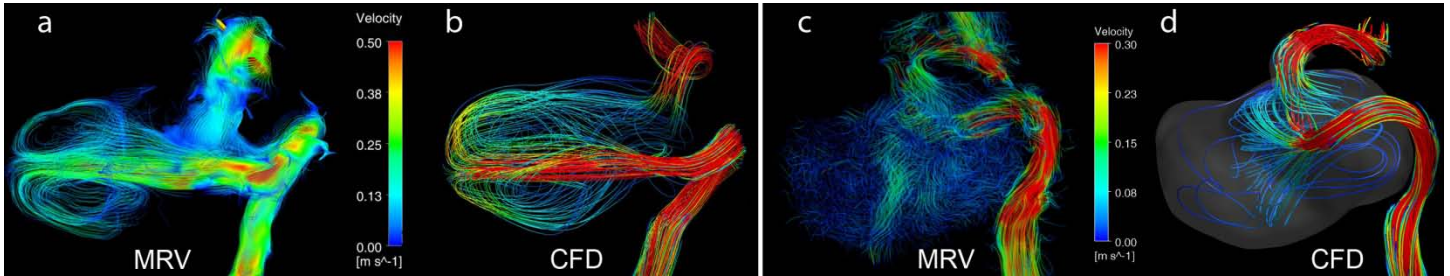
Patient 1: Preoperative streamlines obtained with (a) in vivo PC-MRI, (b) CFD. Postoperative streamlines obtained with (c) in vitro PC-MRI, (d) CFD.
